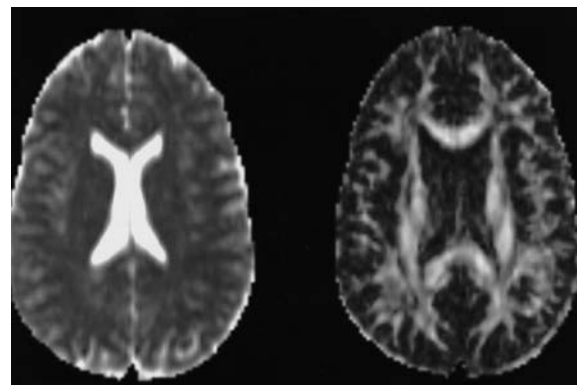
Diffusion-weighted MRI data can be used to generate maps of (left) the apparent diffusion coefficient (ADC) and (right) the anisotropy of diffusion. Diffusion of protons is most rapid and isotropic in cerebrospinal fluid, and least rapid and most anisotropic in white matter. White matter is clearly defined by relative hyperintensity in the anisotropy map.
